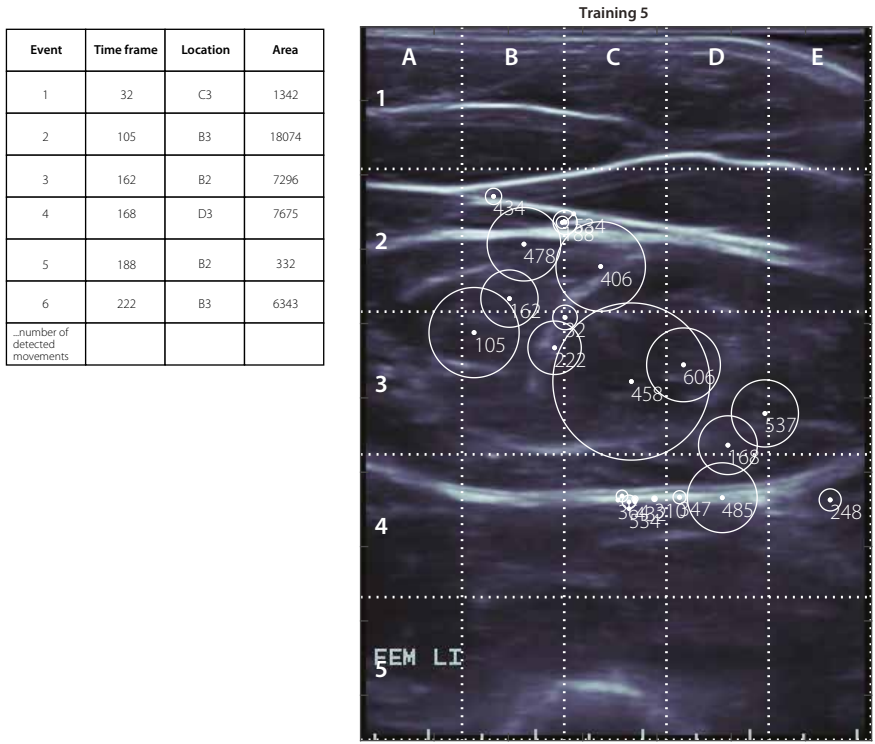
Presentation of the outcome of the developed motion detection method for video #5 from the training-set. The movement events were listed with their corresponding time frame, location and area. Additionally, an ultrasound frame was presented with the events annotated with circles and a time frame stamp, where the radius of the circles represented the involved area of the event.
